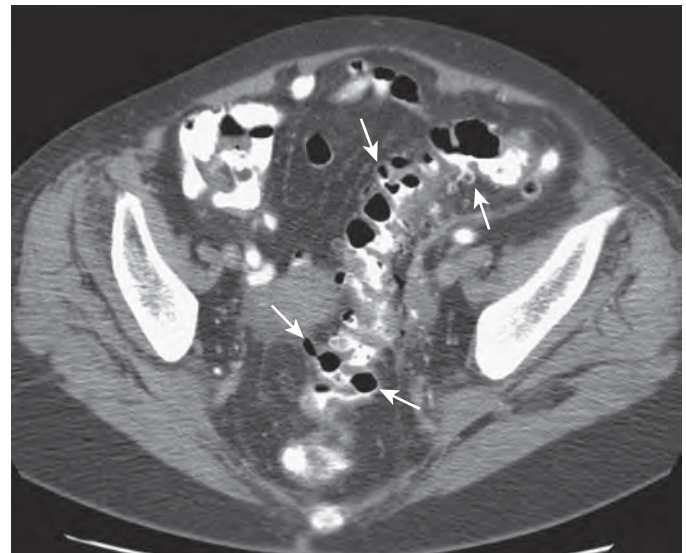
Diverticulosis: CT findings. CT scan at the level of the sigmoid colon shows multiple air- and contrast-filled diverticula (arrows).
